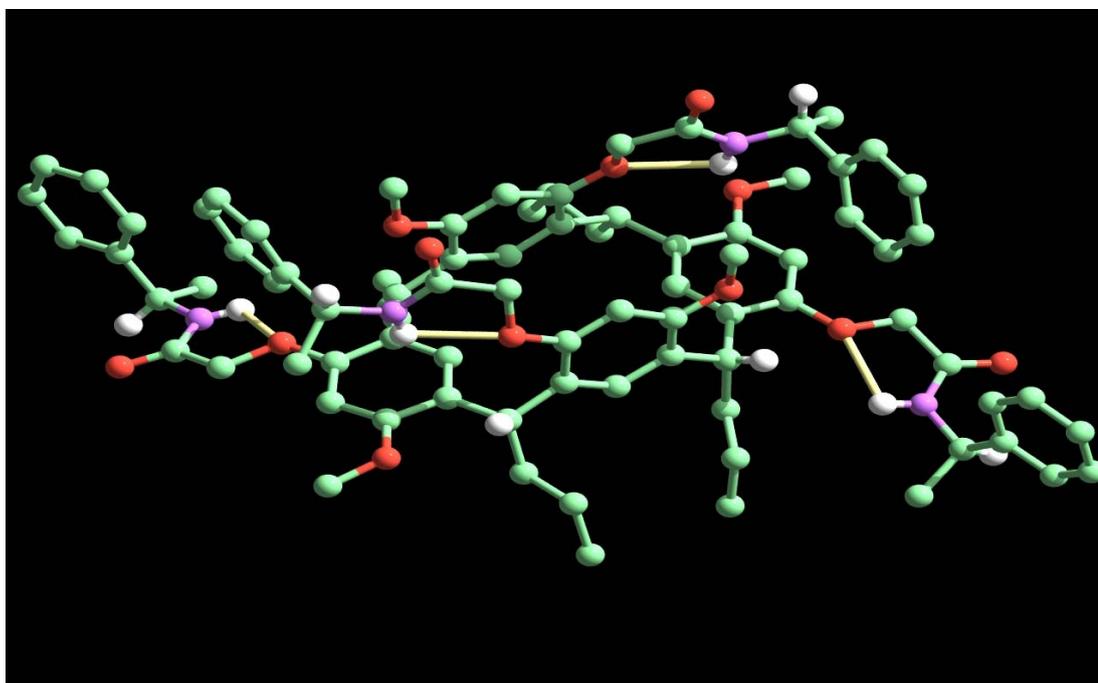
Partial x-ray structure of 2(*R*),4(*R*),6(*R*),8(*R*)-1⁴,3⁶,5⁶,7⁶-tetra-2-oxo-2-[[*(1R)*-1-phenylethyl]amino]ethoxy-1⁶,3⁴,5⁴,7⁴-tetramethoxy-2,4,6,8-tetrapropylresorcin[4]arene (277a, solvent and hydrogen atoms have been omitted for clarity) showing the stereochemistry and hydrogen bonding (gold bonds).
